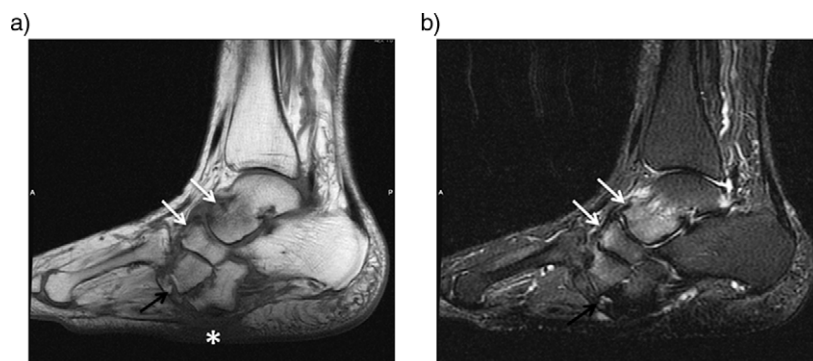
Subacute neuroarthropathy of a 60-year-old woman. Sagittal T1-weighted (a) and T2-weighted fat-suppressed image (b) demonstrates rocker-bottom deformity. There is mild bone marrow edema in talonavicular and tarsometatarsal joints (white arrows) and bony fragments adjacent to lateral cuneiform (black arrows). Note the plantar skin callus beneath the cuboid due to altered biomechanics (asterisk).
